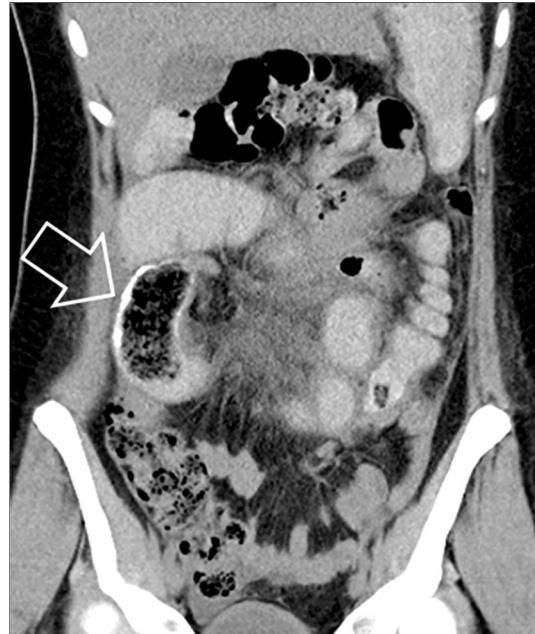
Abdominal CT with intraluminal contrast revealed a marked distention of the proximal jejunal loops, as well as a blindly terminating loop of the small bowel within the right medium abdomen with a diameter of up to 5 cm, containing an obscure mass with the mixed liquid and air bubbles contents, surrounded by heterogeneous high-density walls (arrow). Retrospectively, this finding represents an intraluminal migrated gauze sponge coated with barium.
